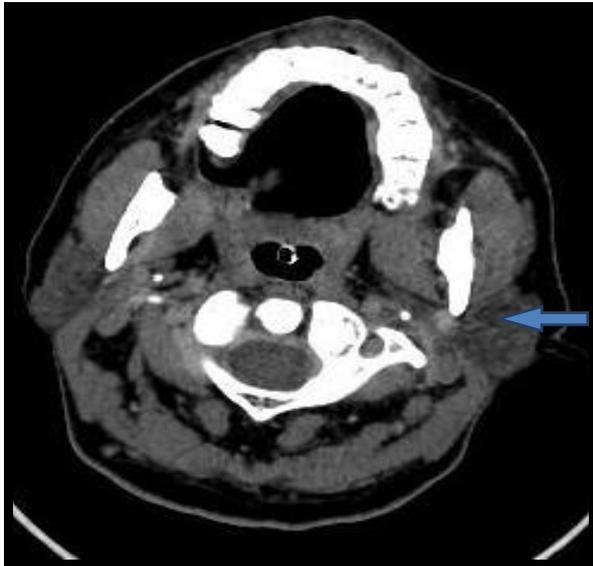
AXIAL CT SCAN showing bulky left parotid
